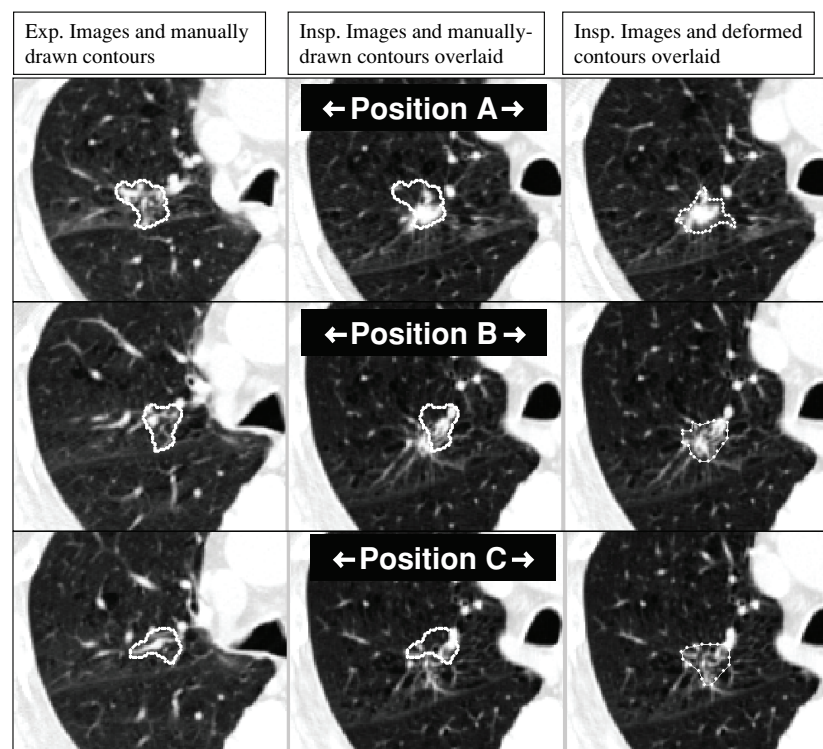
Tumour tracking in 4D CT images of thorax. Each row shows a different axial CT slice. (Left column): Three slices of CT images obtained in end-expiration phase with physician-drawn contours of the tumour. (Middle column): Same contours directly overlaid onto the inspiration CT images. (Right column): Same slices of inspiration CT images overlaid with deformed contours obtained by demons algorithm.
